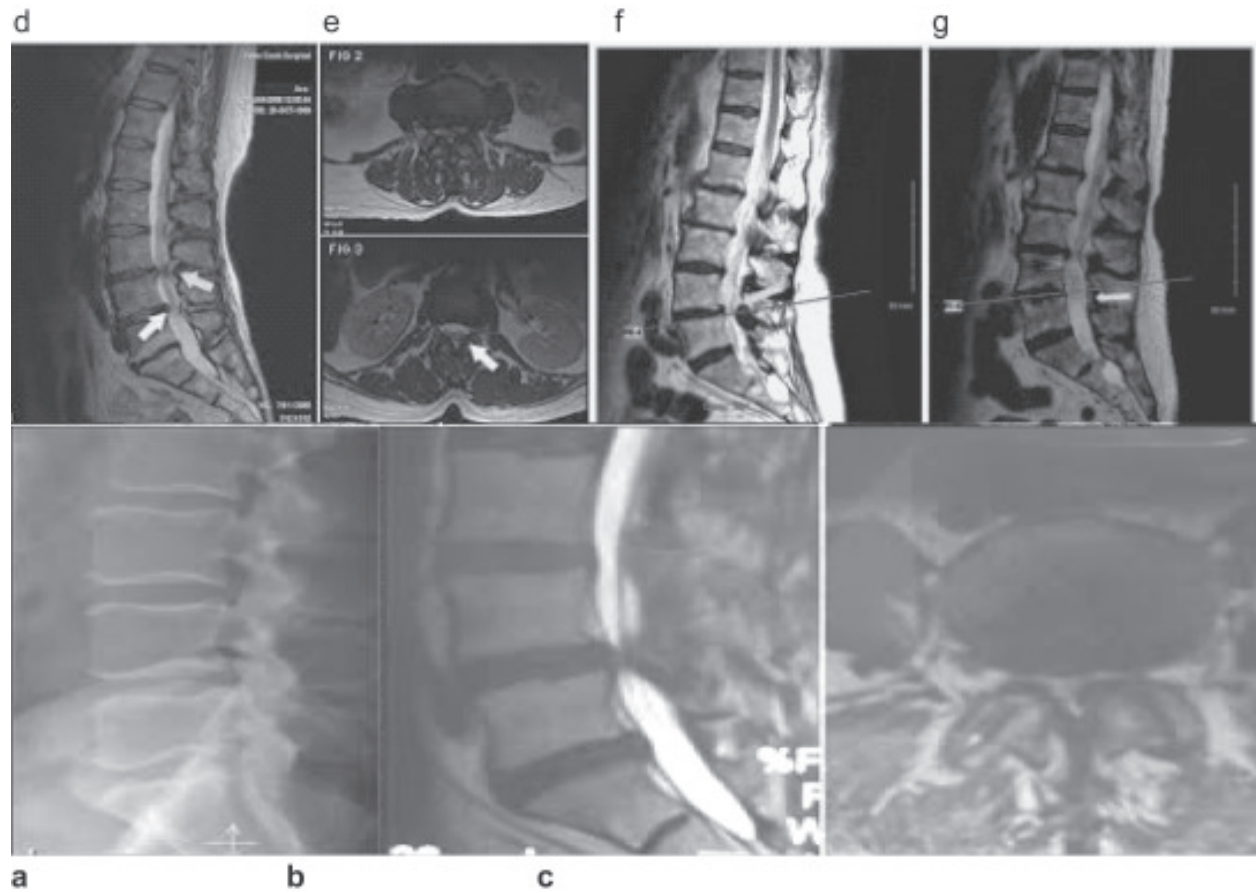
a, plain X-ray, b, d, f and e, c, pre-operative sagittal and axial MRI. g, post operative sagittal MRI
